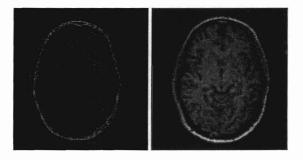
Head CT and T1-weighted MRI
